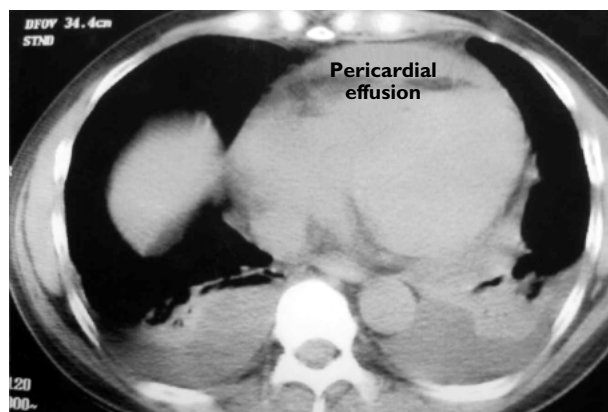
Chest computed tomography scan of the case patient on hospital day 6 showing a large pericardial effusion.
